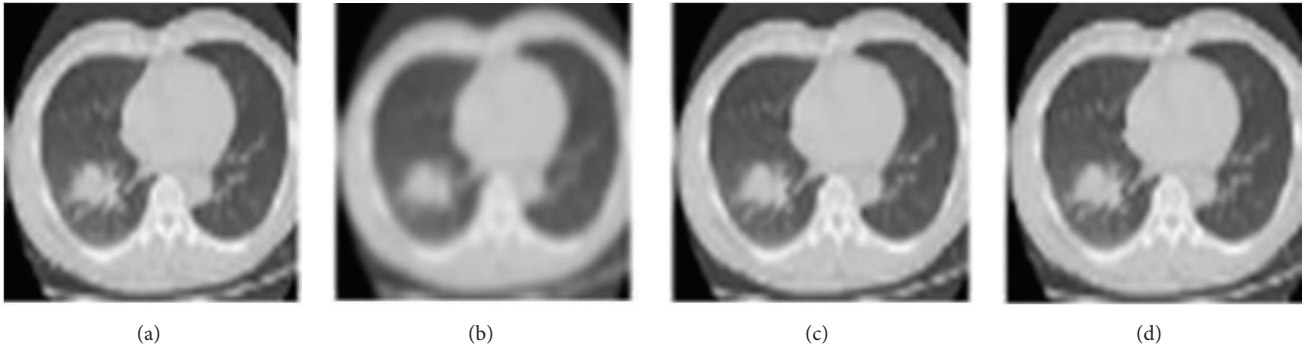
Comparison of CT image smoothing using the guided filter against other filtering methods. (a) Input CT image. (b) Smoothed CT image by Gaussian filter. (c) Smoothed CT image by mean filter. (d) Smoothed CT image by guided filter.
